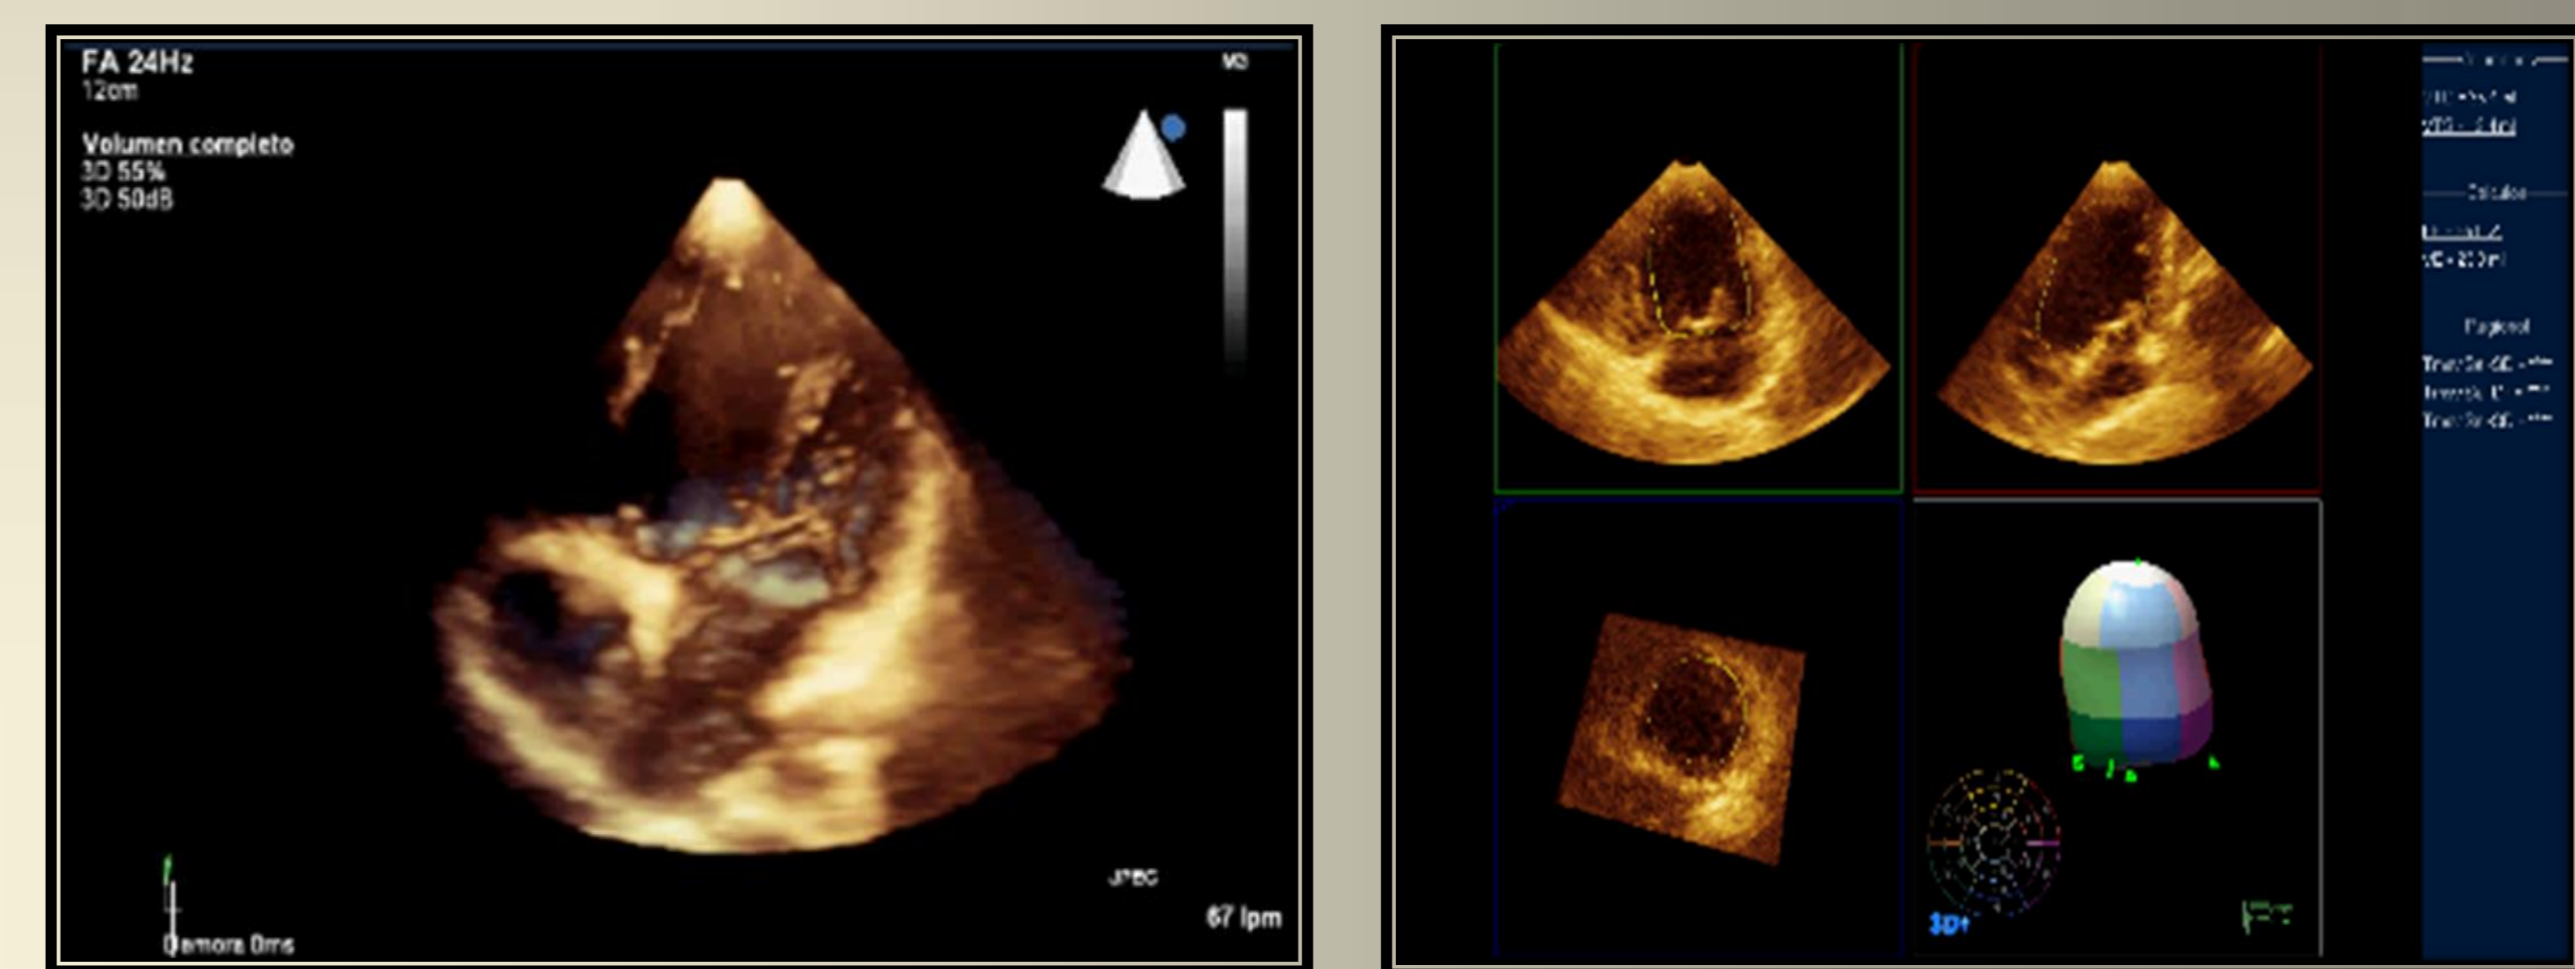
Real Time 3D Echocardiography. Evaluation of Ejection fraction (EF). Diastolic, Systolic and Stroke Volume (Main ventricle left morphology)
